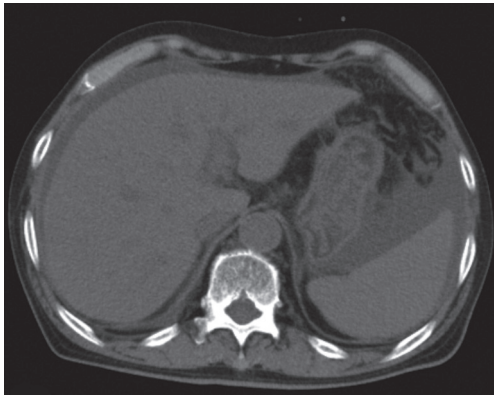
Computed tomography scan on admission shows that the liver was not cirrhotic or nodular. Moderate ascites can be observed.
